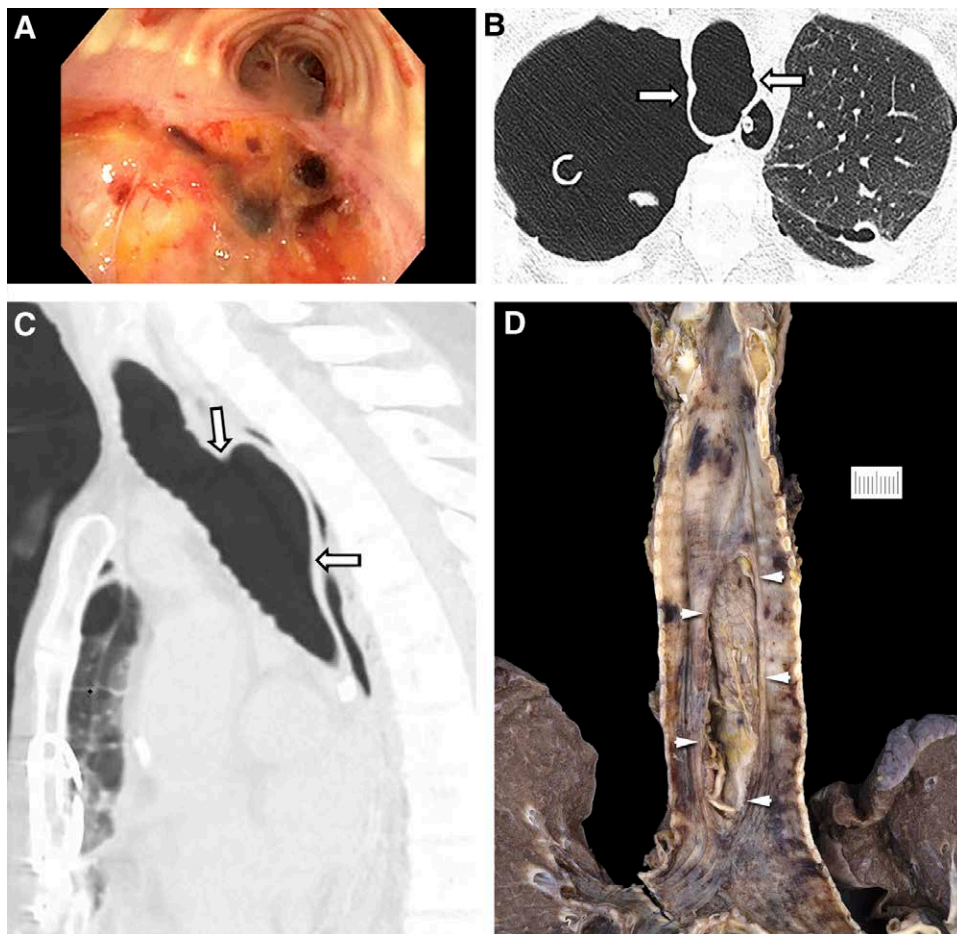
A, Bronchoscopy image demonstrating diverticulum in the posterior (membranous) wall of the trachea. B and C, Post-lung transplant axial and coronal HRCT demonstrate a wide-based diverticulum or outpouching of the posterior (membranous) wall of the intrathoracic trachea measuring $47 \times 22 \times 21$ mm in maximal craniocaudal, anteroposterior, and transverse dimensions (between the white arrows). D, The trachea on autopsy is opened anteriorly to demonstrate the tear in the posterior (membranous) wall of the trachea (indicated by the white arrows). The adventitia of the esophagus is visible underneath the tear. HRCT, high-resolution computed tomography.
